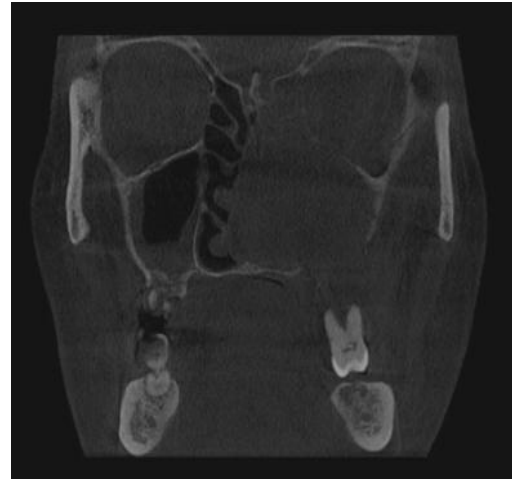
Coronal section of CBCT.
